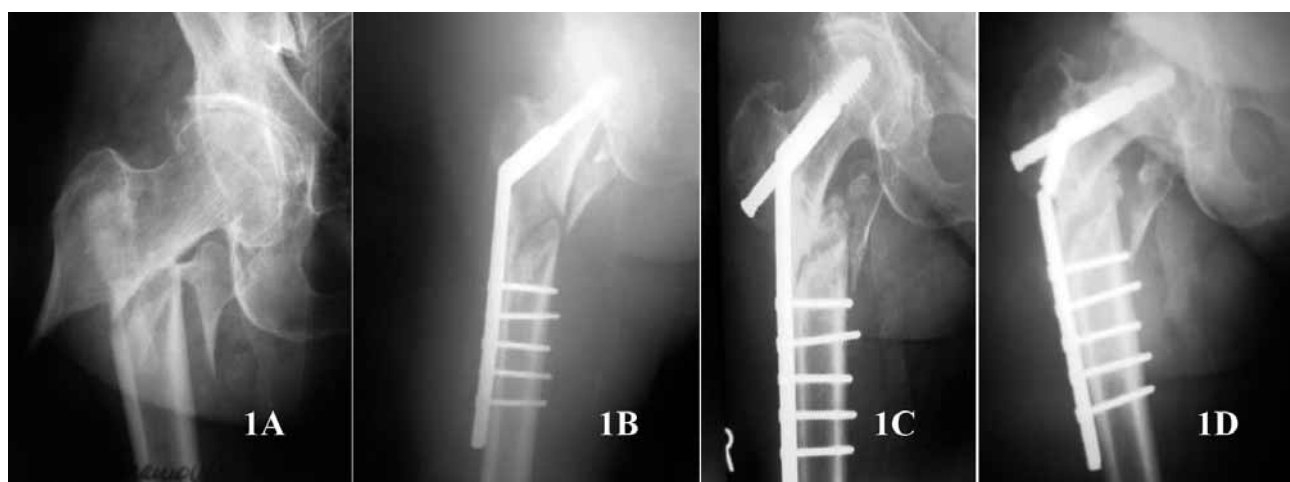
A – radiograph showing an unstable trochanteric fracture AO-OTA 31 A 3.3. B – apparently satisfactory reduction of the fracture with the unsolved posteromedial cortical deficiency treated with SHS. C – signs of uncontrolled impaction and shaft medialization. D – signs of non-union and fatigue failure of the implant.
